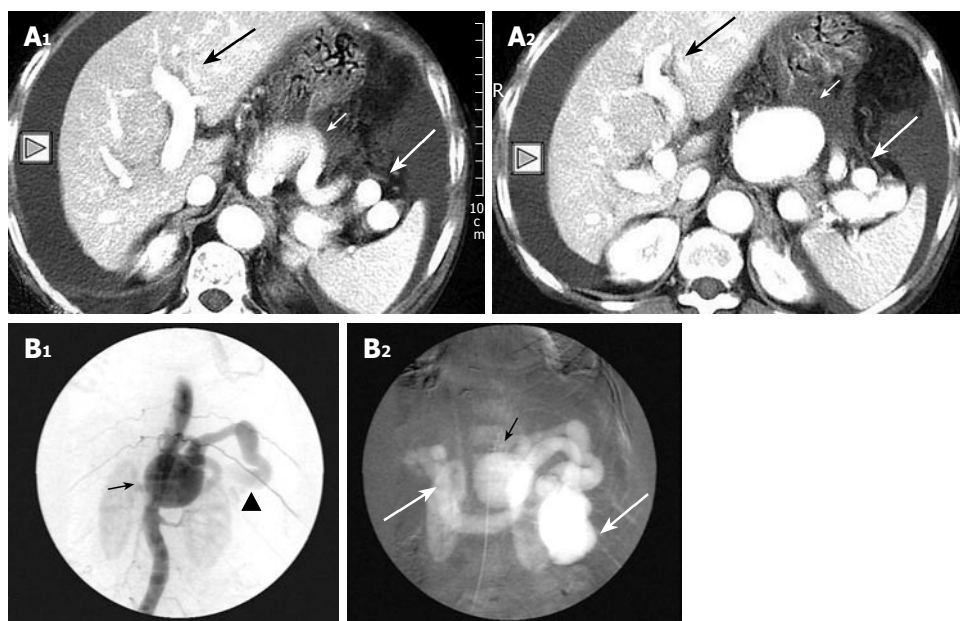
A: Post contrast CT scan reveals a tortuous and aneurysmatic splenic artery of maximum diameter of approximately 52 mm (short white arrow) associated with dilated vessels at the splenic hilum (long white arrow) and early opacification of the portal axis (long black arrow). In addition ascites is present as well (small triangle); B: Celiac angiogram confirms the presence of the splenic artery aneurysm (black arrow) in contiguity with the markedly dilated splenic vein and the premature and intense filling of the splenoportal trunk (black arrowhead and white arrows).
